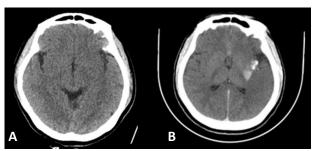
Head CT Scan. (A); Before and (B); after thrombectomy.
